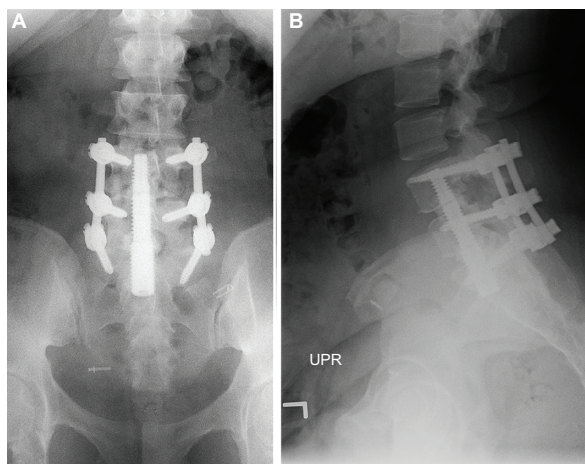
Anteroposterior and lateral radiographs demonstrating two-level interbody fusion with AxiaLIF implant with bilateral pedicle screw fixation.
